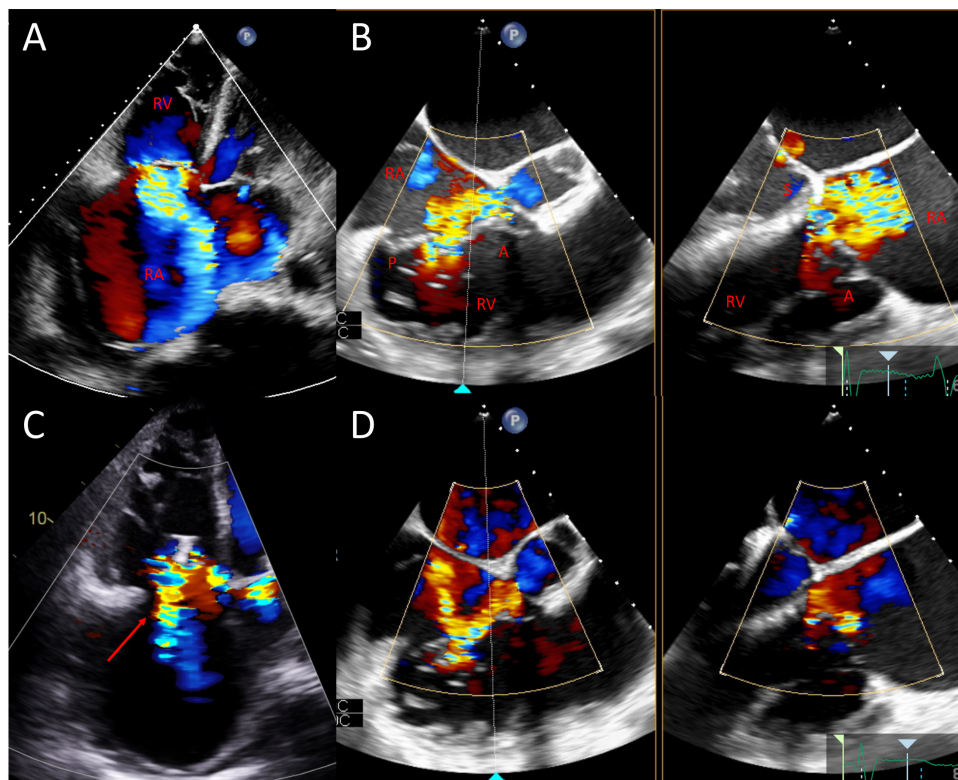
Preprocedural massive tricuspid regurgitation in (A) transthoracic apical 4-chamber and (B) transoesophageal tricuspid valve inflow-outflow view with X-plane. C and D: Clip was deployed between the anterior and septal leaflets with reduction in tricuspid regurgitation (red arrow). A: Anterior tricuspid leaflet; P: Posterior tricuspid leaflet; RA: Right atrium; RV: Right ventricle; S: Septal tricuspid leaflet
